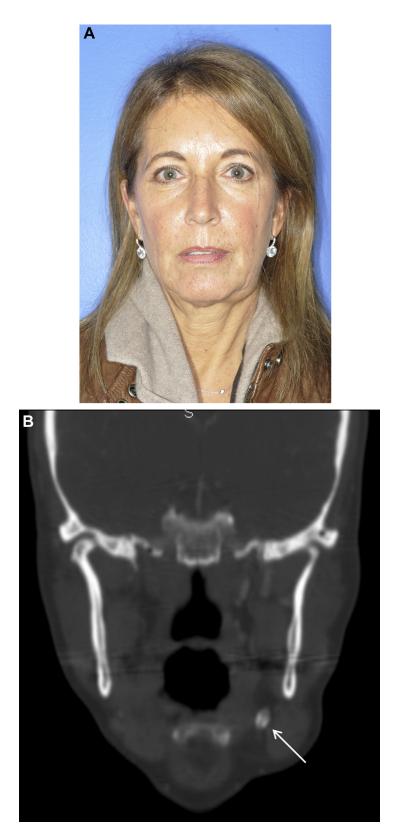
A*, Patient at presentation with a left submandibular swelling. *B*, Computed tomogram, coronal view, depicts enlargement of the submandibular gland, with a large hyperdense lesion (*arrow*), probably a sialolith, in the hilus of the gland.
